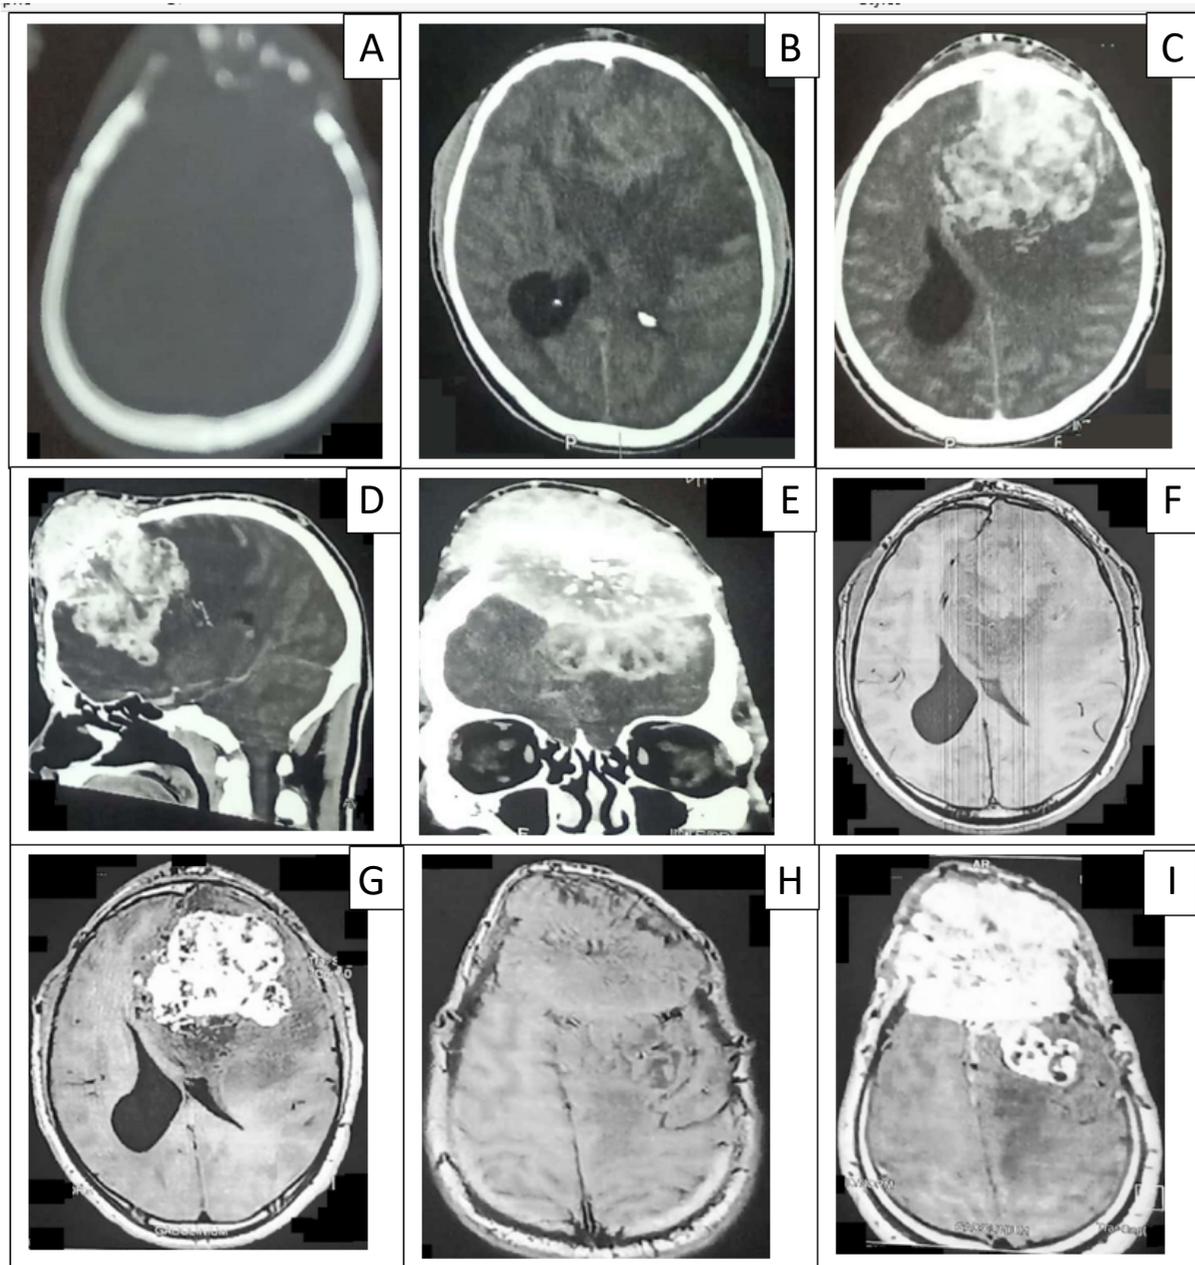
Pre-operative imaging. Preoperative computerized tomography (CT) scan, axial section in bone window (A); parenchymal window without (B); and with (C) contrast product injection; computerized tomography (CT) injected in sagittal (D) and coronal (E) reconstruction; magnetic resonance imaging (MRI) in T1-weighted sequence in axial section passing through the Ventricles without (F) and with (G) contrast products injection; magnetic Resonance imaging (MRI) in T1-weighted sequence in axial section passing over the ventricles without (H) and with (I) contrast products injection
